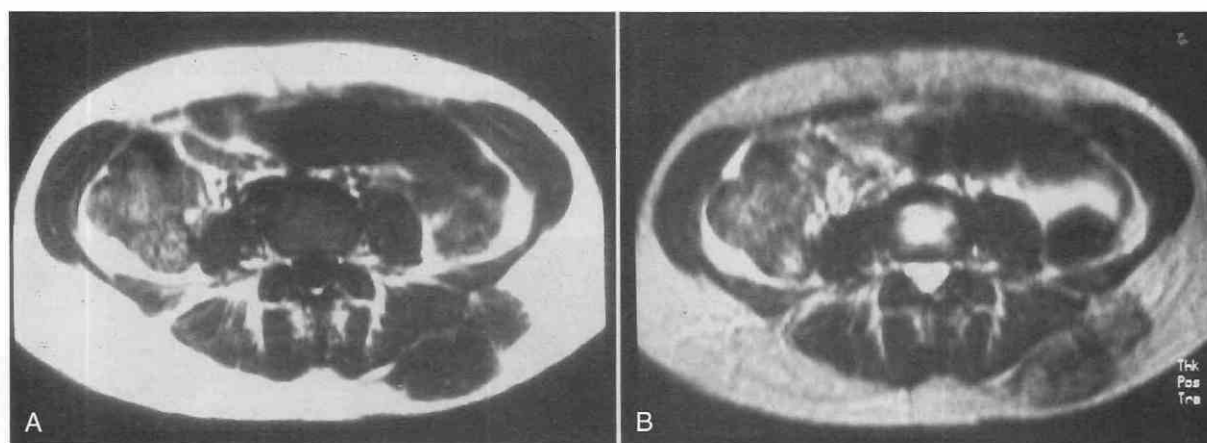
Desmoid tumor. Axial spin-echo images, T1-weighted axial spin echo (A) (TR = 540 msec, TE = 15 msec) and T2-weighted axial spin echo (B) (TR = 2000 msec, TE = 80 msec) demonstrate a lesion in the subcutaneous tissues of the back. The T1-weighted image (A) shows low signal intensity; the T2-weighted image (B) shows intermediate signal intensity and an area of low signal intensity. The low signal intensity seen on each sequence suggests fibrous tissue and aids in the diagnosis.
